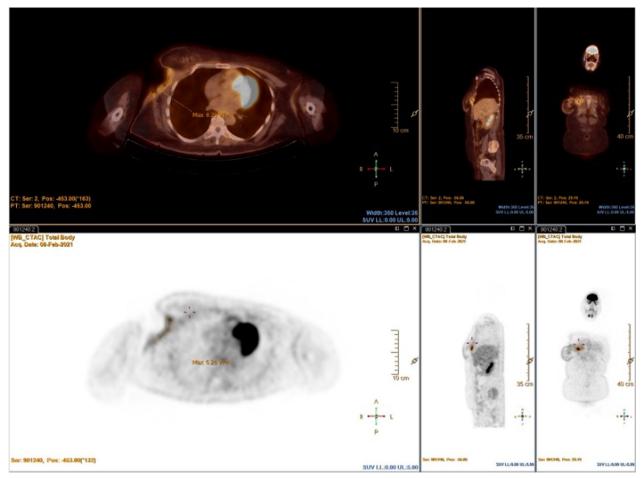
18F-FDG-PET/CT findings of PBL in the same patient, after 6 cycles of R-CHOP. The images show a decrease in size of the right breast lesion with intense FDG uptake (SUV <sub>max</sub> = 6.3), consistent with partial response
